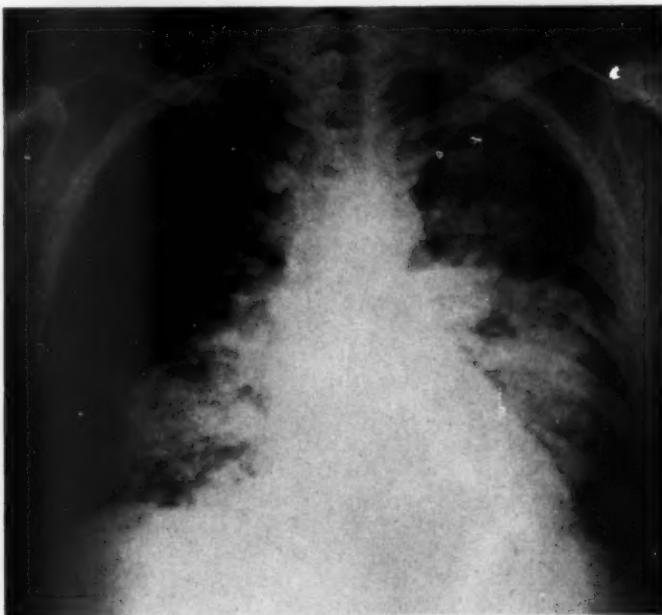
Roentgenogram taken nine days after exposure to carbon tetrachloride fumes, showing fluffy hilar shadows. (A. F. I. P. Acc. No. 168546, photograph No. 95268.)
